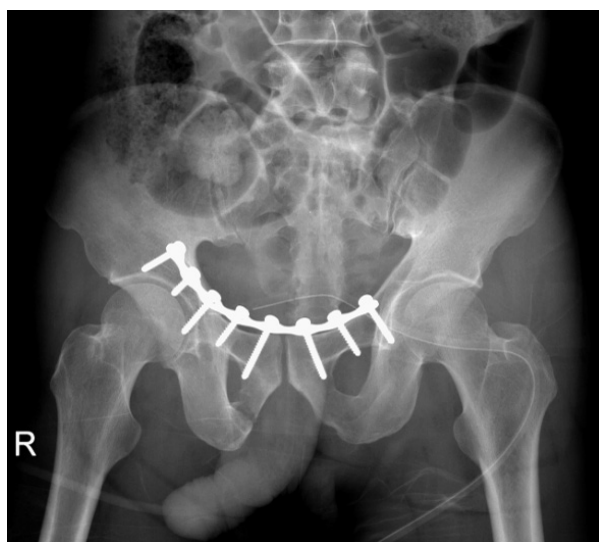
The first postoperative radiograph shows open reduction and internal fixation of the anterior ring of the pelvis by modified Stoppa approach.
